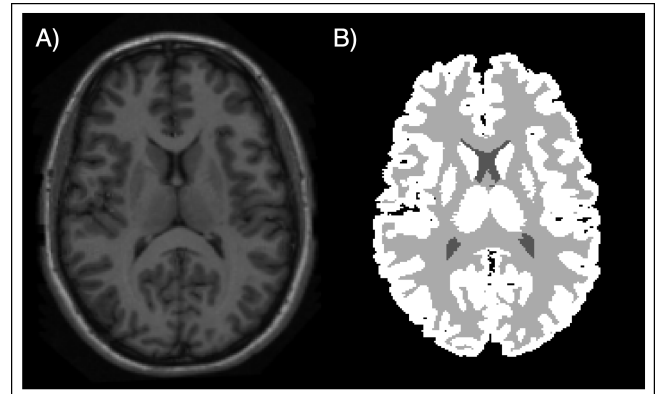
An example of the different modalities of the dataset A) T1-weighted B) GT
